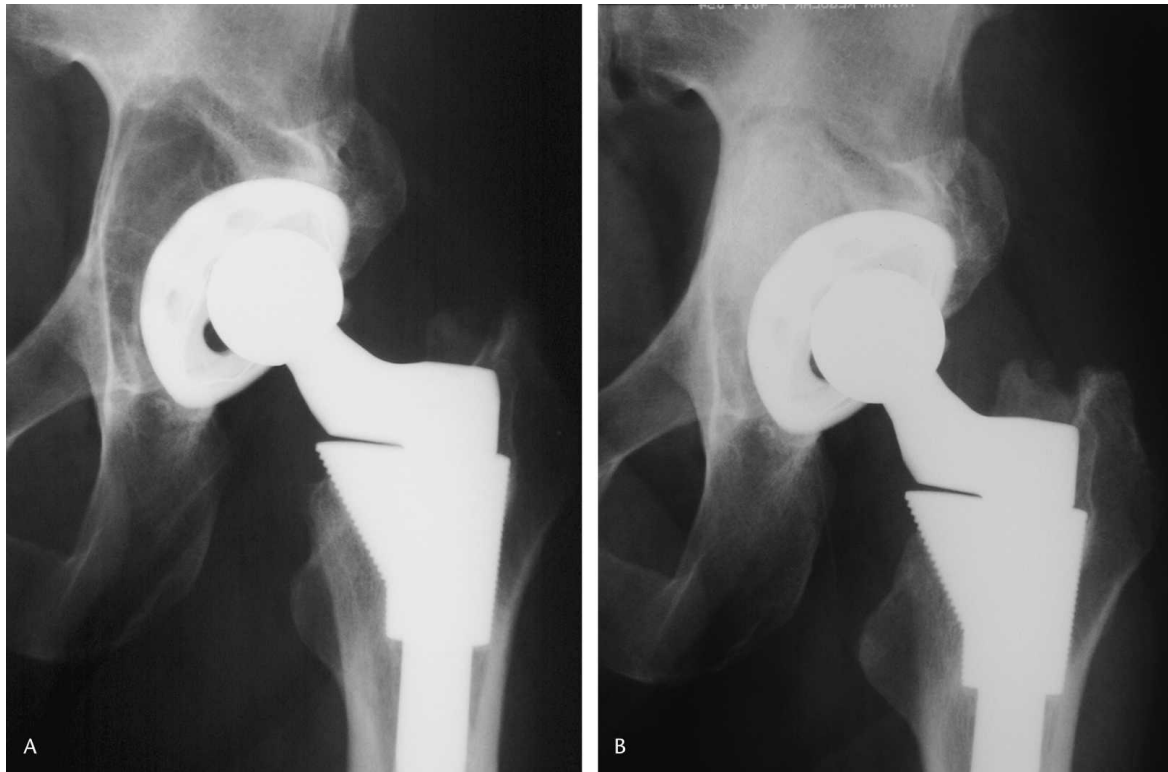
(A) An AP radiograph of the right hip shows a 43-year-old man who presented with osteolysis secondary to PE wear 8 years after primary cementless THA. The patient had an S-ROM[®] femoral component (previously Joint Medical Products, Stamford, CT, now DePuy, a Johnson & Johnson Company, Warsaw, IN) with a 28-mm standard neck Co-Cr femoral head, and a DuraLoc[®] acetabular component with Hylamer[®] liner (DePuy) for treatment of posttraumatic arthritis. (B) A postoperative radiograph shows well fixed components and satisfactory positioning and alignment 44 months after the patient had surgical treatment of the head and liner removal, grafting with morselized allograft bone, and implantation of an Enduron[®] liner with a 28 mm cobalt chromium femoral head with a neck length of 3 mm.
